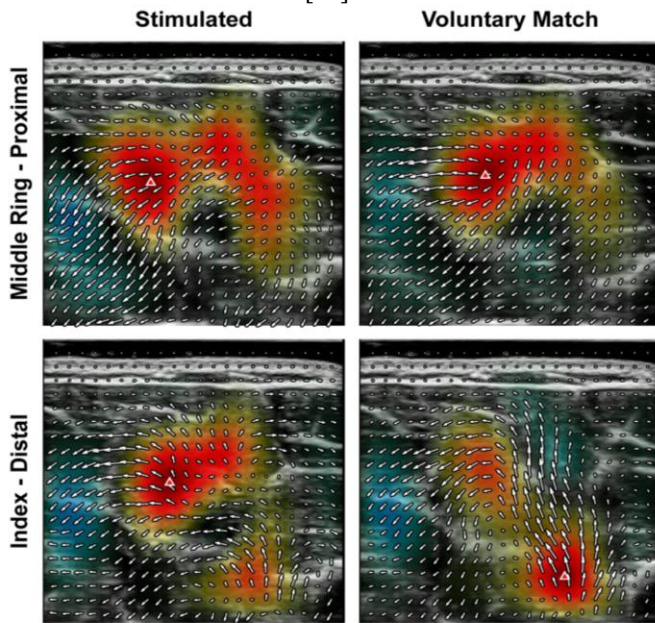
Sample Ultrasound Deformation and Divergence for a Single Subject. Each image represents the total image deformation and divergence from each stimulated location and its matched-voluntary movement. The red triangles indicate the precise location of the maximum divergence value. Rows represent a single stimulated motion pattern, and the columns represent the movement condition. Of note is the bottom row which also contains an example of divergence maps with two distinct local maxima.
